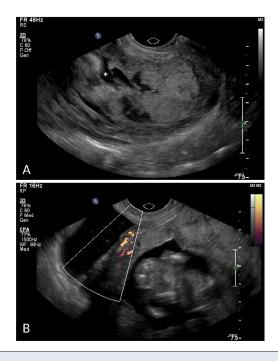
(A): Sonographic image of placenta demonstrating large, placental vascular lacunae (asterisk). (B): Color Doppler image demonstrating hypervascularity with invasion of the placenta into the lower uterine segment.
